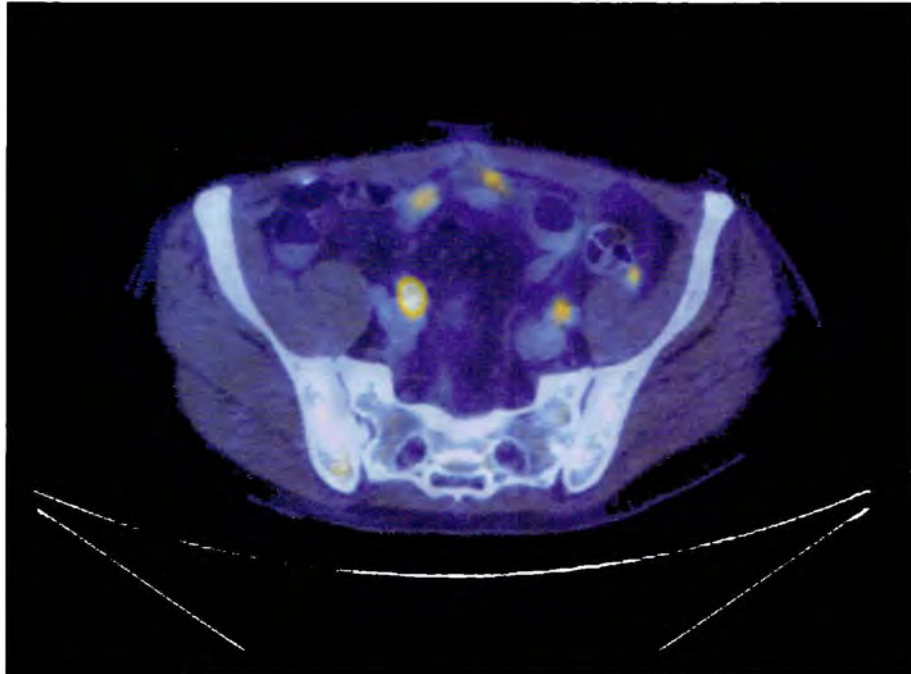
Additionally, there is enlarged right posterior iliac chain lymph node with a SUVmax of 6.9. These findings are strongly suspicious for colon cancer metastasis to the bone, liver and peritoneum.
